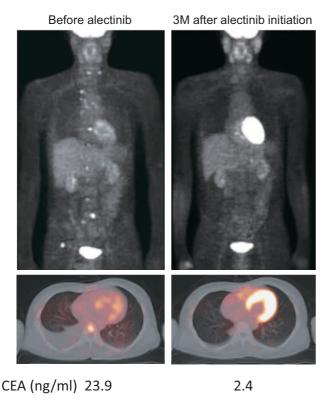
Effect of ALK inhibitor alectinib at the post-surgical recurrence. FDG-PET scan before and 3 months after the initiation of alectinib treatment (300 mg twice a day).
